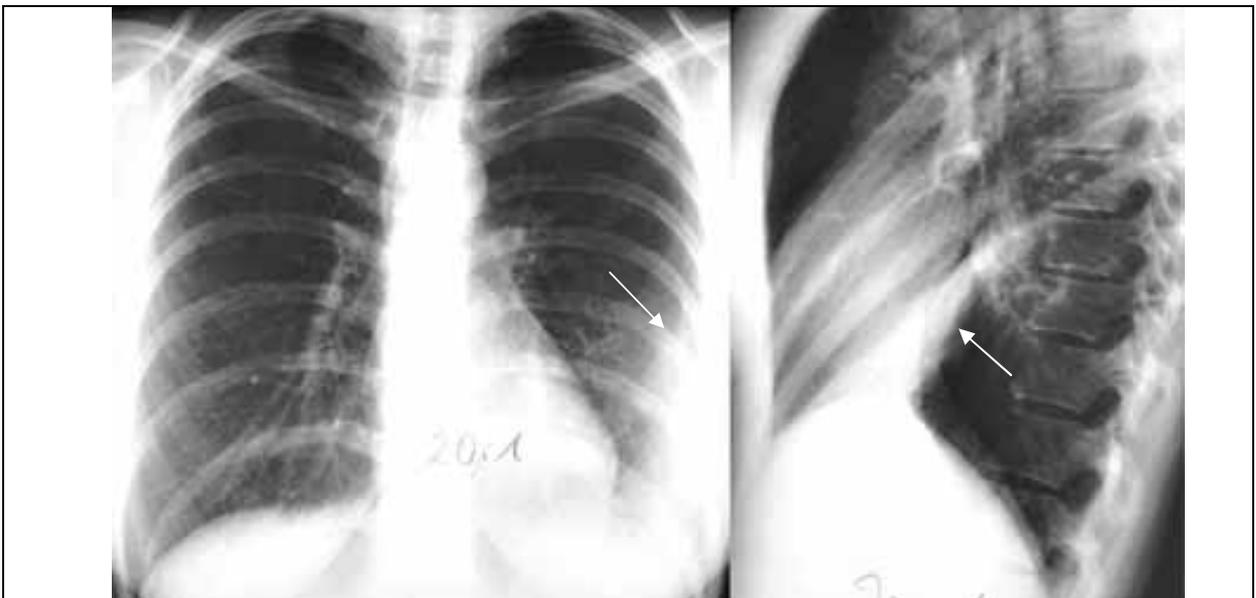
Survey radiographs of a thorax in direct and lateral projections. There is a limited shadow of homogeneous structure, the triangular form (arrows) in projection VIII segment of the lower lobe of the left lung.
